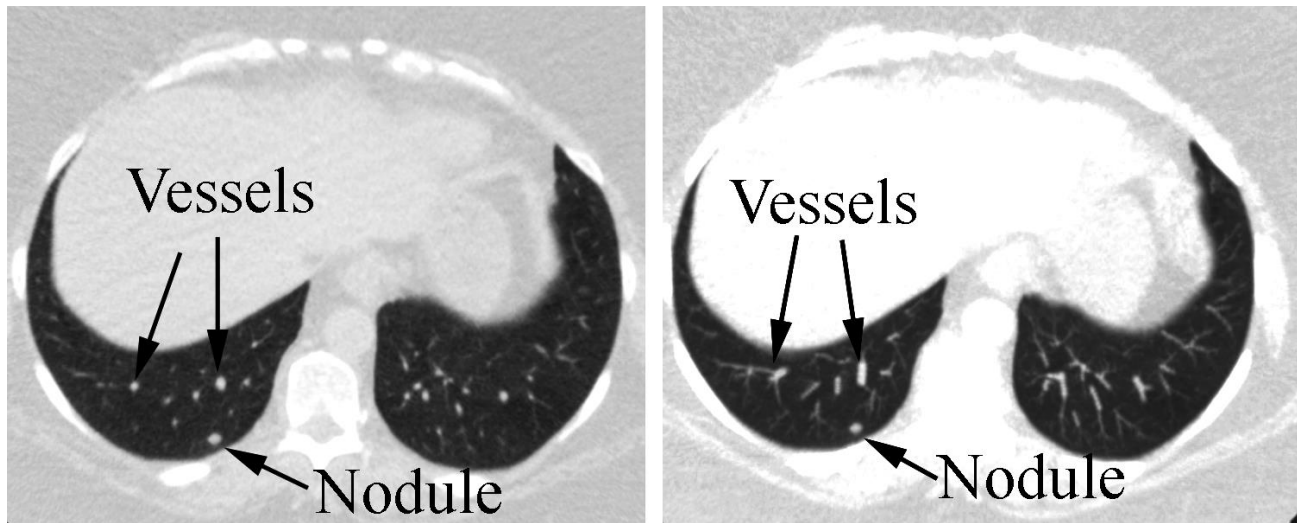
Chest CT exam showing the value of “Maximum Intensity Projections” or “MIPs”. A. Routine chest CT filmed at lung windows shows a similar appearance for both the nodules and the vessels (imaged “on end”). B. MIP CT image demonstrates that these 10 mm thick slices (which record only the densest pixels from the slab) show the nodule as an oval density (as before), but the vessels as tubular, branching structures. These images make evaluation of the lung parenchyma for small nodules much easier.
